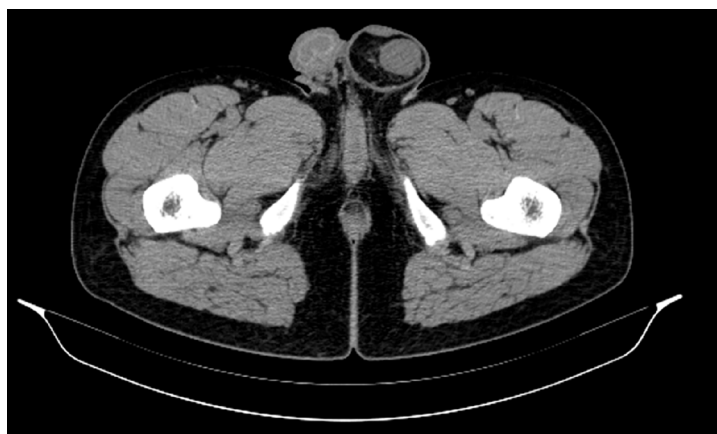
Pelvic computed tomography findings. Pelvic computed tomography showed that intraperitoneal fat herniate in the left scrotum through widened left inguinal canal, and there is a mass appearing as soft tissue density in hernia contents with a size of approximately 2.5 cm × 1.3 cm × 3.0 cm.
